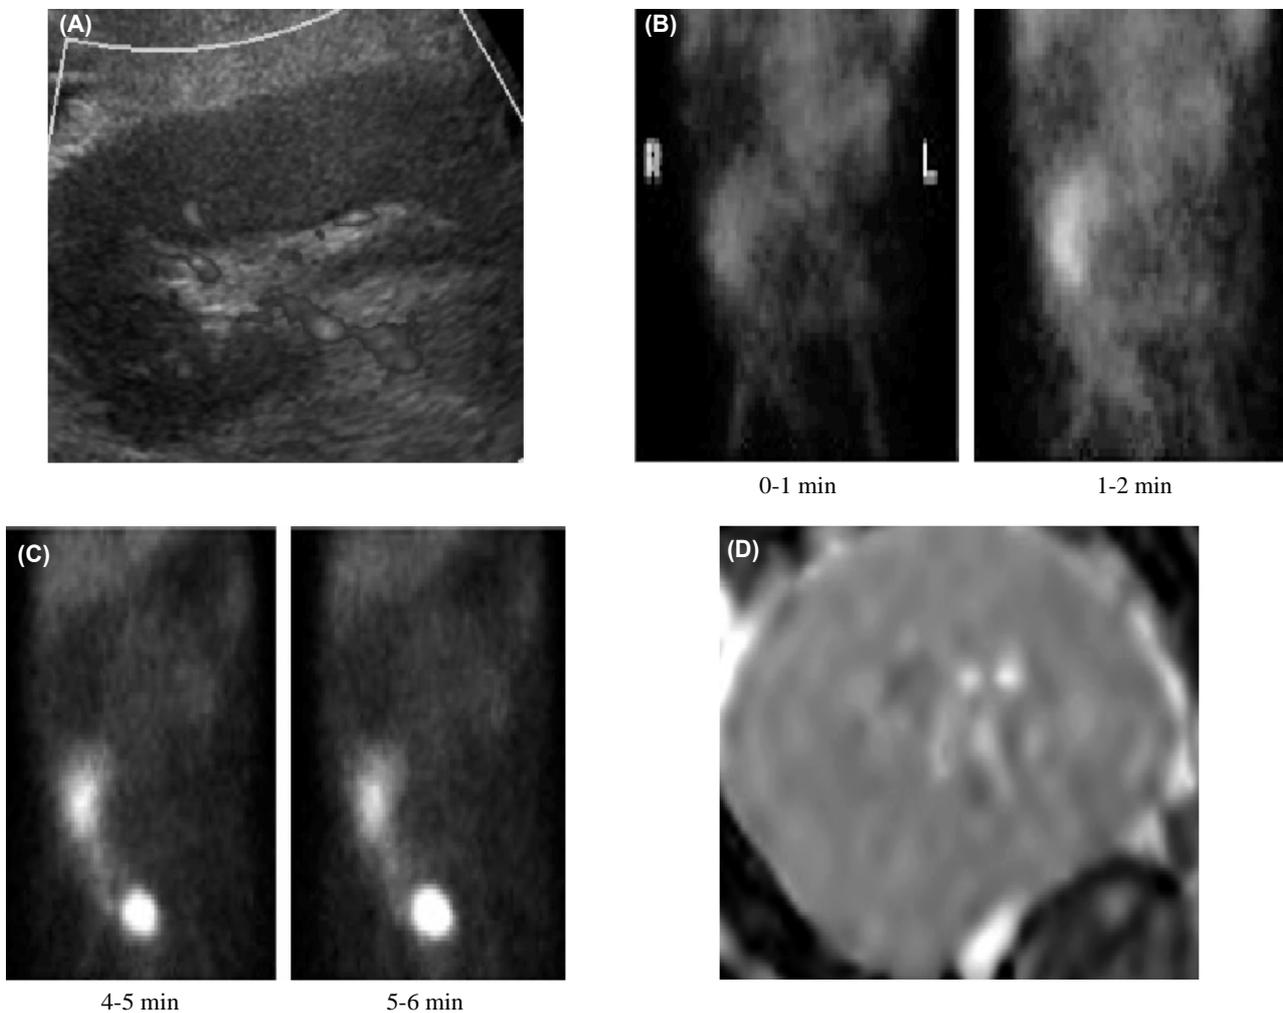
A 43-year-old male patient presented with rising serum creatinine and relatively reduced urine output. That was diagnosed as Acute Rejection by imaging; and confirmed by graft biopsy. (A): Routine US and Doppler was done revealed reduced intra-parenchymal perfusion. (B): Diuretic renography (perfusion phase) shows reduced renal perfusion in comparison to aorta and iliac vessels. (C): Diuretic renogram (parenchymal uptake) shows reasonable uptake of the renal parenchyma. (D): ADC axial image shows relatively diffuse low ADC map.
